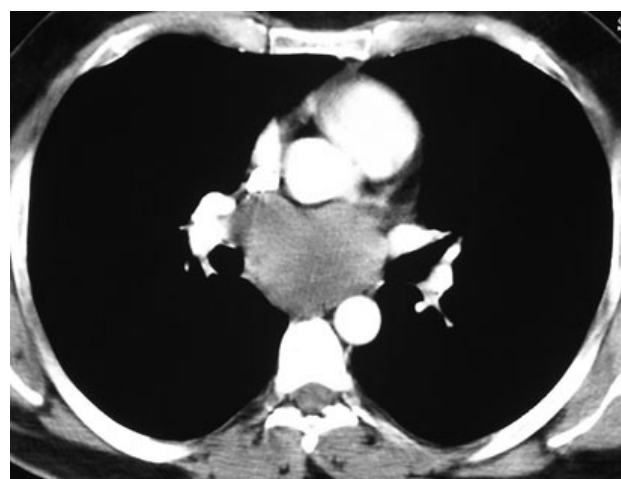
Thorax CT showing subcarinal cystic lesion.
